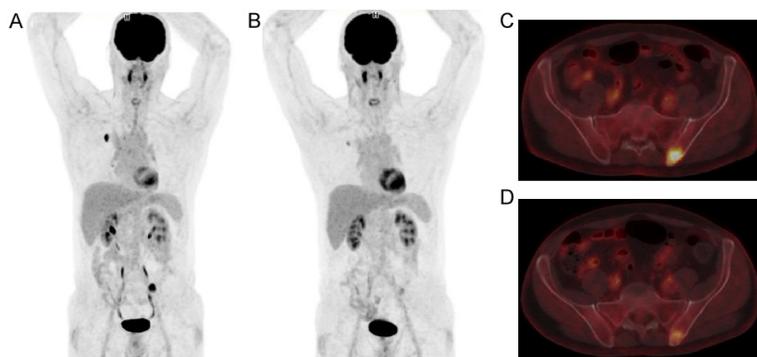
Patient example with whole body PET scan and trans axial fused PET/CT: A 58-year-old male before (A and C) and after 9 days of erlotinib treatment (B and D) with partial metabolic response for all methods.
